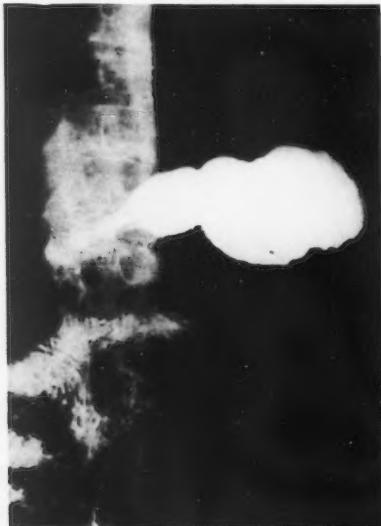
G.G. Gastrointestinal roentgenographic series revealed a horizontal "cup and spill" type stomach with constant narrowing of the distal portion of the stomach.
